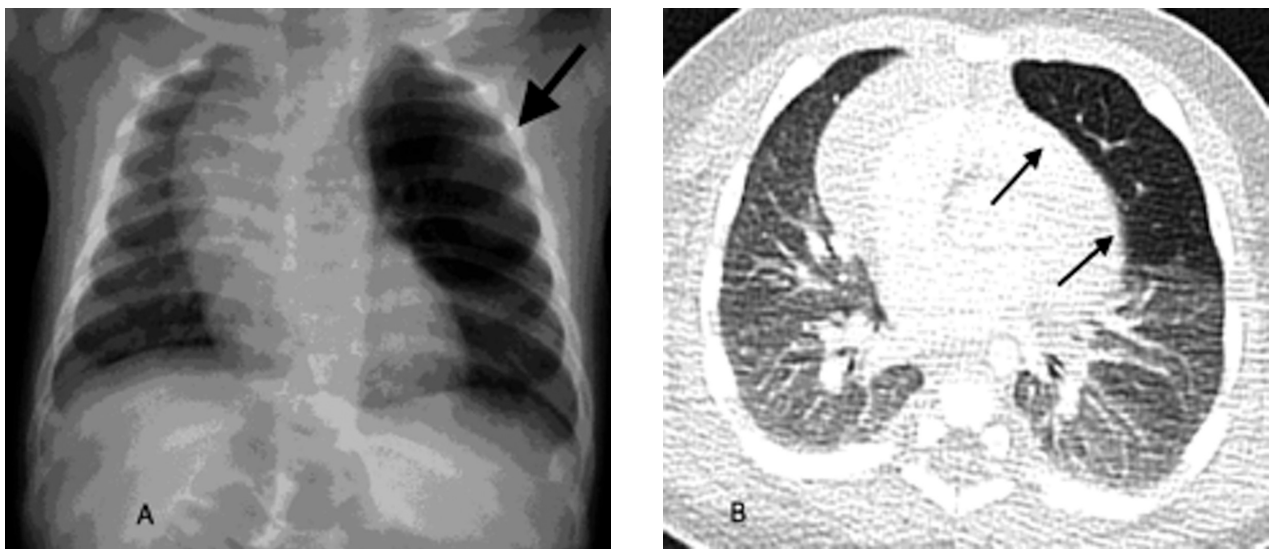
(A) XR shows an hyperlucency in the left upper lobe which displaces the contralateral upper mediastinum. (B) CT detects an increased radiolucency and distension of the left upper lobe; it is associated contralateral dislocation of the mediastinum
